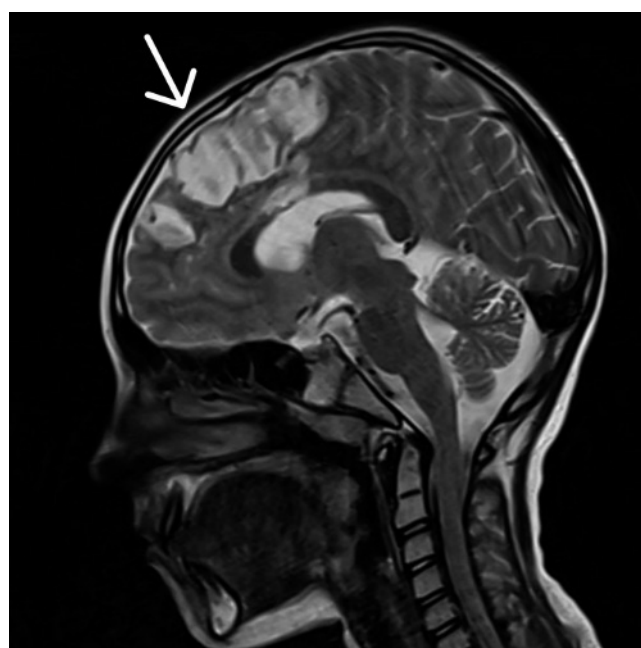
Follow-up head MRI showing regression of the haemorrhagic and thrombotic changes
